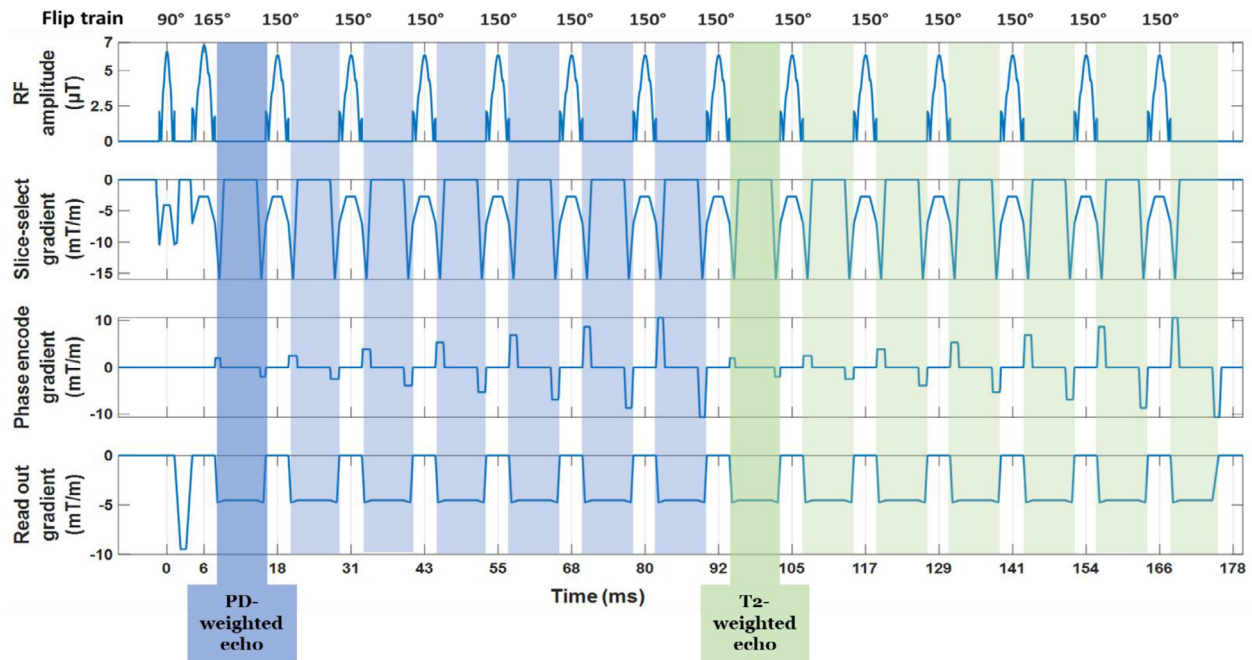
Example dual-echo FSE pulse sequence using TE1 12.3 ms, TE2 99 ms and echo spacing 12.3 ms. The first seven echoes (blue) form the PD-weighted image and the next 7 echoes (green) the T2-weighted image. Centric phase encode order was used for both images with the effective TEs shown. Sequence variants between sites/vendors all use centric phase encoding. The most significant differences between vendors/sites was the refocusing pulses and flip angles. In this example from vendor 1, the flip angle train is 90°- 165°- 150°- 150°-.... The excitation and refocusing RF pulses were 2.56 ms and 3.85 ms in duration with the flat central portion of the RF pulse corresponding to a gradient strength of 0.4 G/cm for excitation and 0.27 G/cm for the refocusing. (For interpretation of the references to color in this figure legend, the reader is referred to the web version of this article.)
